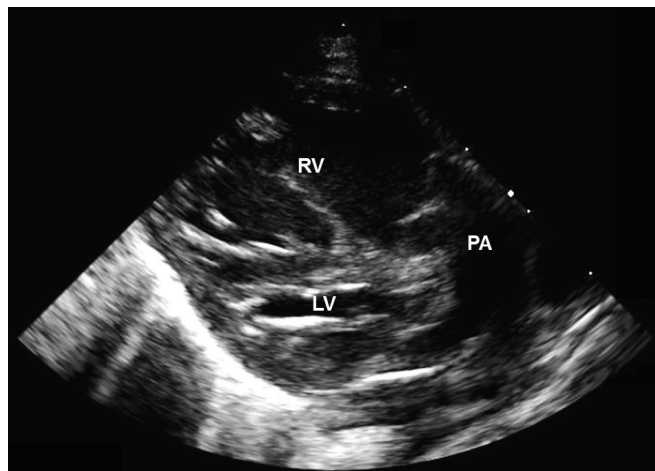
Transthoracic echocardiogram demonstrating hypoplastic left ventricle.
